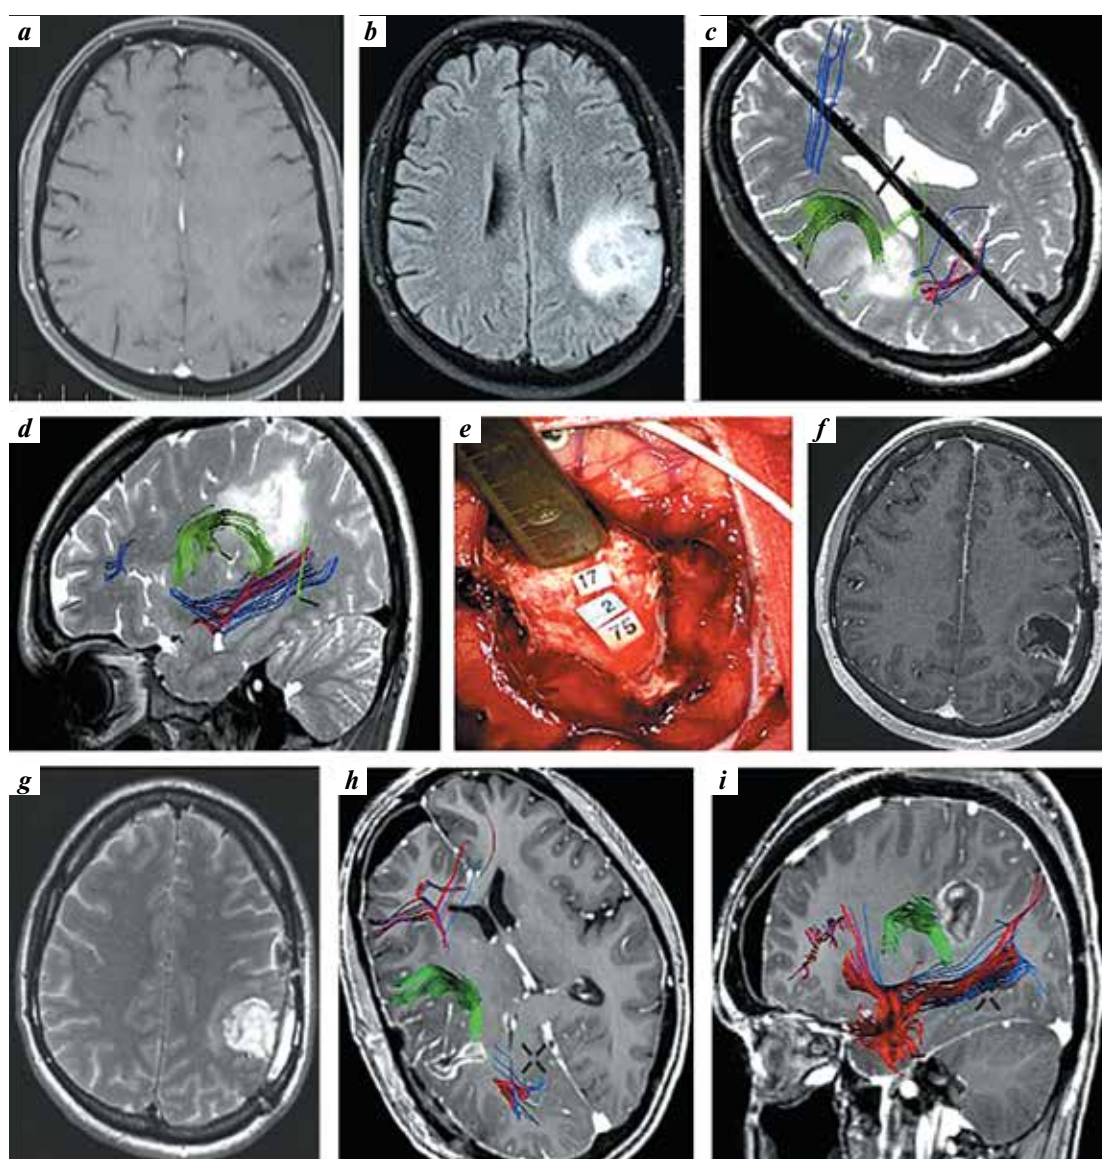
Data of female patient S.: a, b – magnetic resonance imaging (MRI) before surgery: axial scans in contrast-enhanced T1-weighted (a) and T2 FLAIR modes (b); c, d – magnetic resonance tractography before surgery: arcuate fasciculus (infiltrated) is shown in green: it is incorporated into the tumor along the posterior boundary; inferior fronto-occipital (shown in blue) and inferior longitudinal (shown in red) fasciculi are intact; e – intraoperative image: figures 2, 17, 75 denote the arcuate fasciculus; f, g – MRI after surgery: axial scans in contrast-enhanced T1-weighted (f) and T2-weighted modes (g); h, i – magnetic resonance tractography after surgery: arcuate fasciculus is shown in green, it is located near the postoperative cavity, inferior fronto-occipital and inferior longitudinal fasciculi are intact
